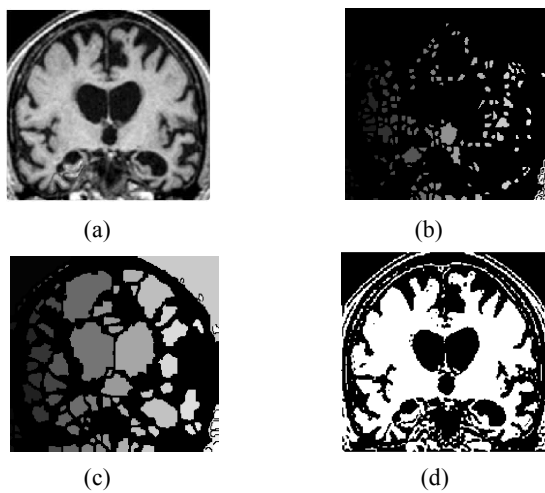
Atrophied Brain MRI: (a) Original (b) watershed segmented (c) segmented with the proposed approach (d) segmented with the traditional method
